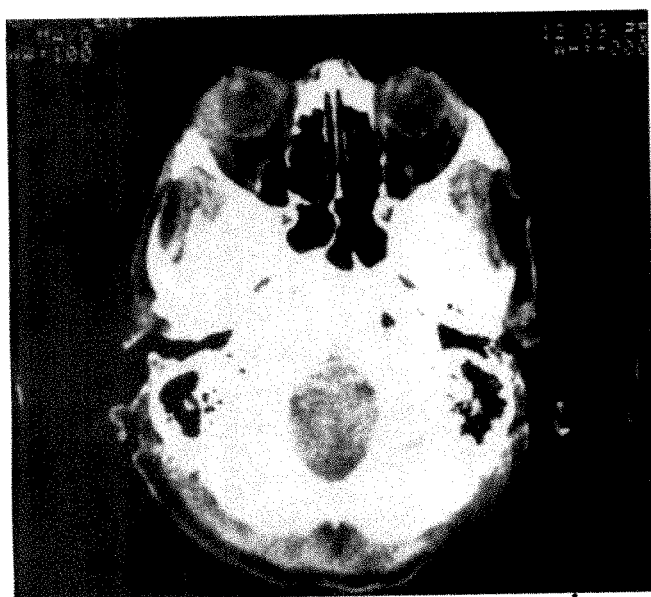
CT scan of 74-year-old man with slight proptosis on left. Small high density mass located lateral to left globe. Patient has not yet had surgery, but tumor probably in lacrimal gland.
